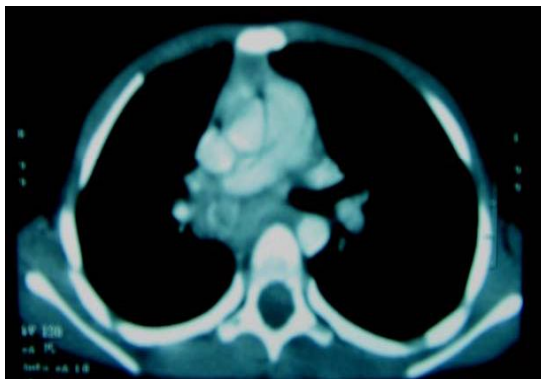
Pre-contrast CT chest showing a right hilar rounded "mass" with rim calcification
